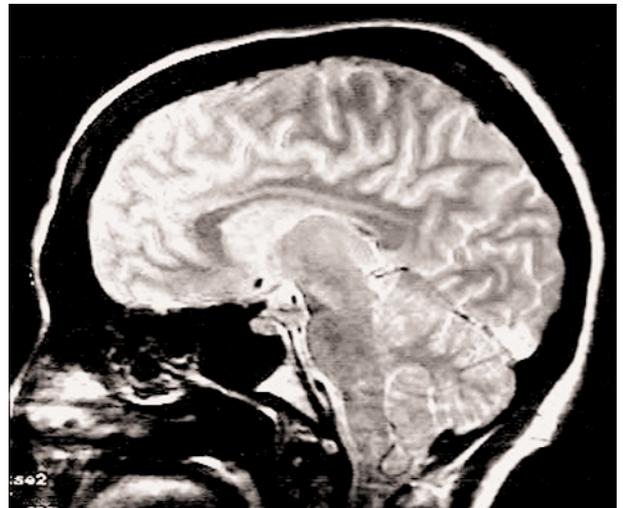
MRI scan of the brain showing the ventral lateral, centromedian, ventral posteromedial nuclei
